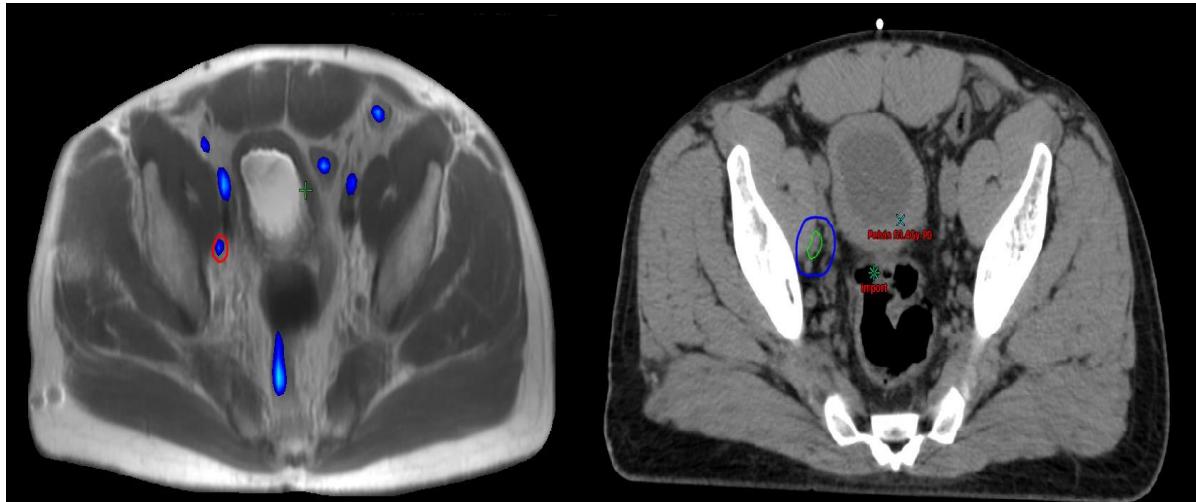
Example of fluciclovine-PET/MRI directed radiotherapy treatment planning. Left image shows the $[^{18}\text{F}]$ fluciclovine PET-MRI with lower window of PET window set to 1.3 times blood pool. The suspicious LN is segmented in red. Right image is the treatment planning CT for the same patient with $\text{CTV}_{\text{LN BOOST}}$ delineated in green and the associated PTV in blue.
